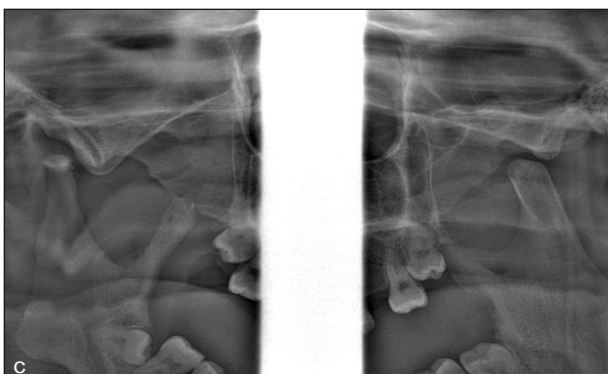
Cone beam computed tomography. (a) Coronal view of the TMJs that shows irregular surface of the right mandibular condyle and sclerotic changes with focal erosion of the left mandibular condyle. (b) Axial view of the TMJs that shows osteodystrophy of the right mandible and mandibular asymmetry.
